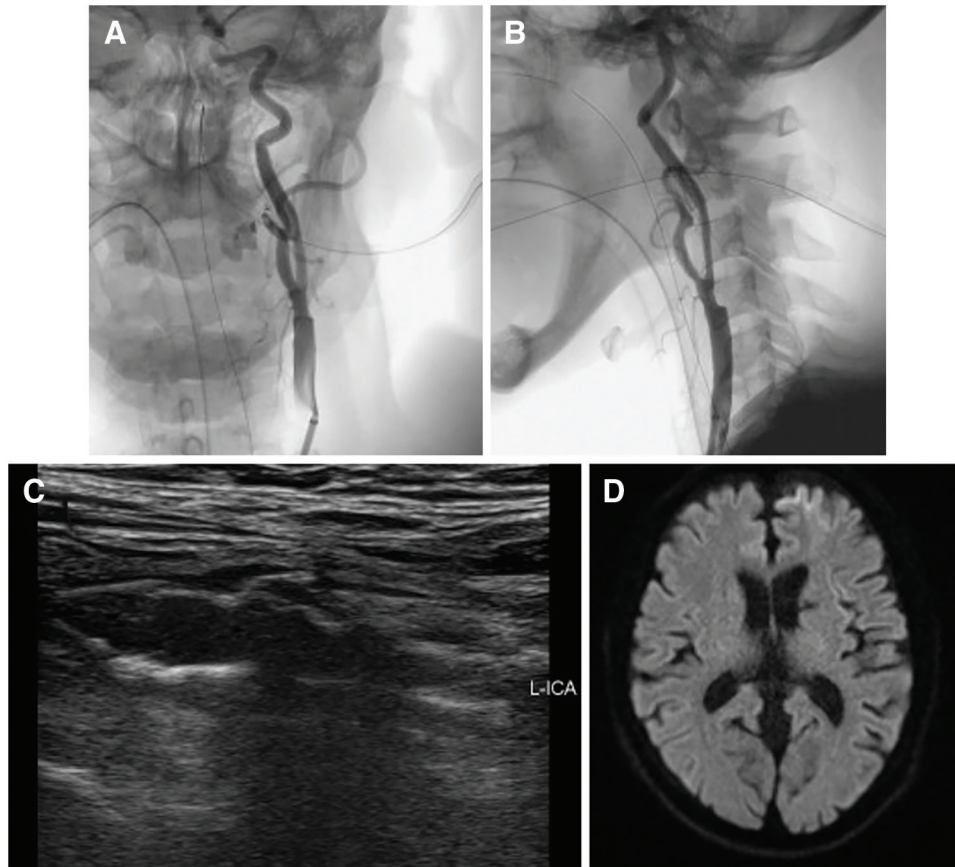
Postoperative imaging: left cervical angiogram AP view (A), LAT view (B), ultrasonogram (C), and head MRI (DWI) (D). Improvement of the stenosis was observed. No obvious PP or in-stent thrombus was observed. No obvious cerebral infarction was observed. AP: anteroposterior; DWI: diffusion-weighted imaging; LAT: lateral; PP: plaque protrusion
